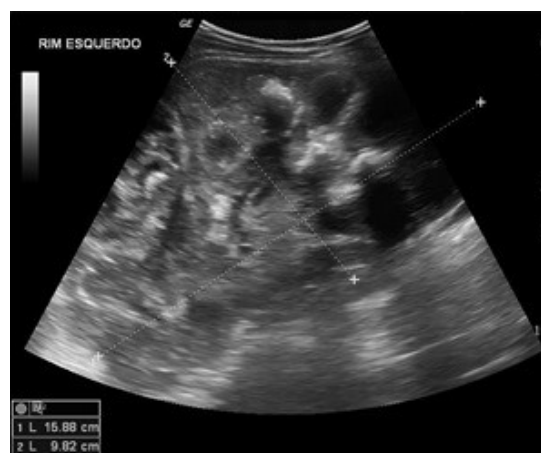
Abdominal ultrasound – left kidney hydronephrosis, measuring 15,88 x 9,82cm.
